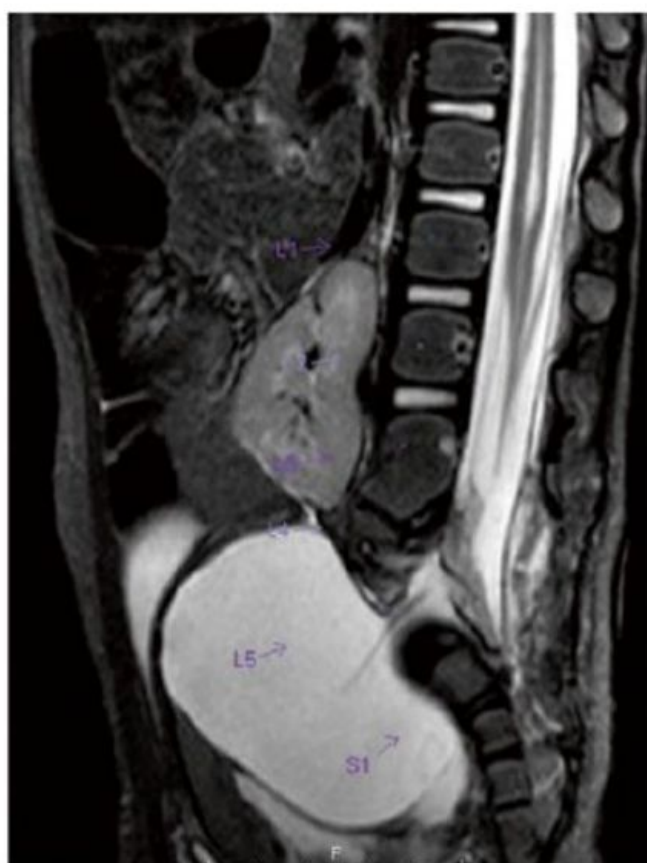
MR image of a presacral mass with an anterior meningocele
